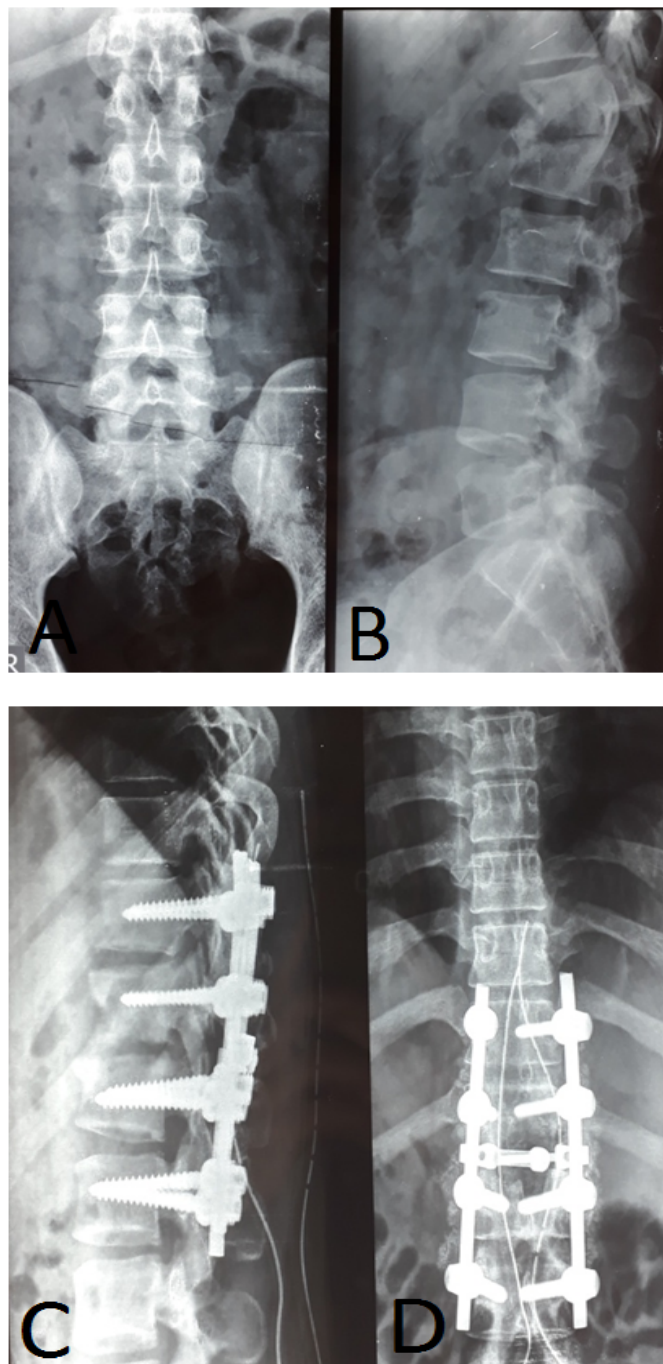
A.B.C.D. Tuberculosis spondylitis Th XII – L 1, with destruction in a 25-year-old male. Preoperative X-rays. (A) Anterior-posterior view and (B) lateral view. Pedicle screw – rod system fixation followed by decompression and fusion. Postoperative X-rays. (C) Anteroposterior view and (D) lateral view.
